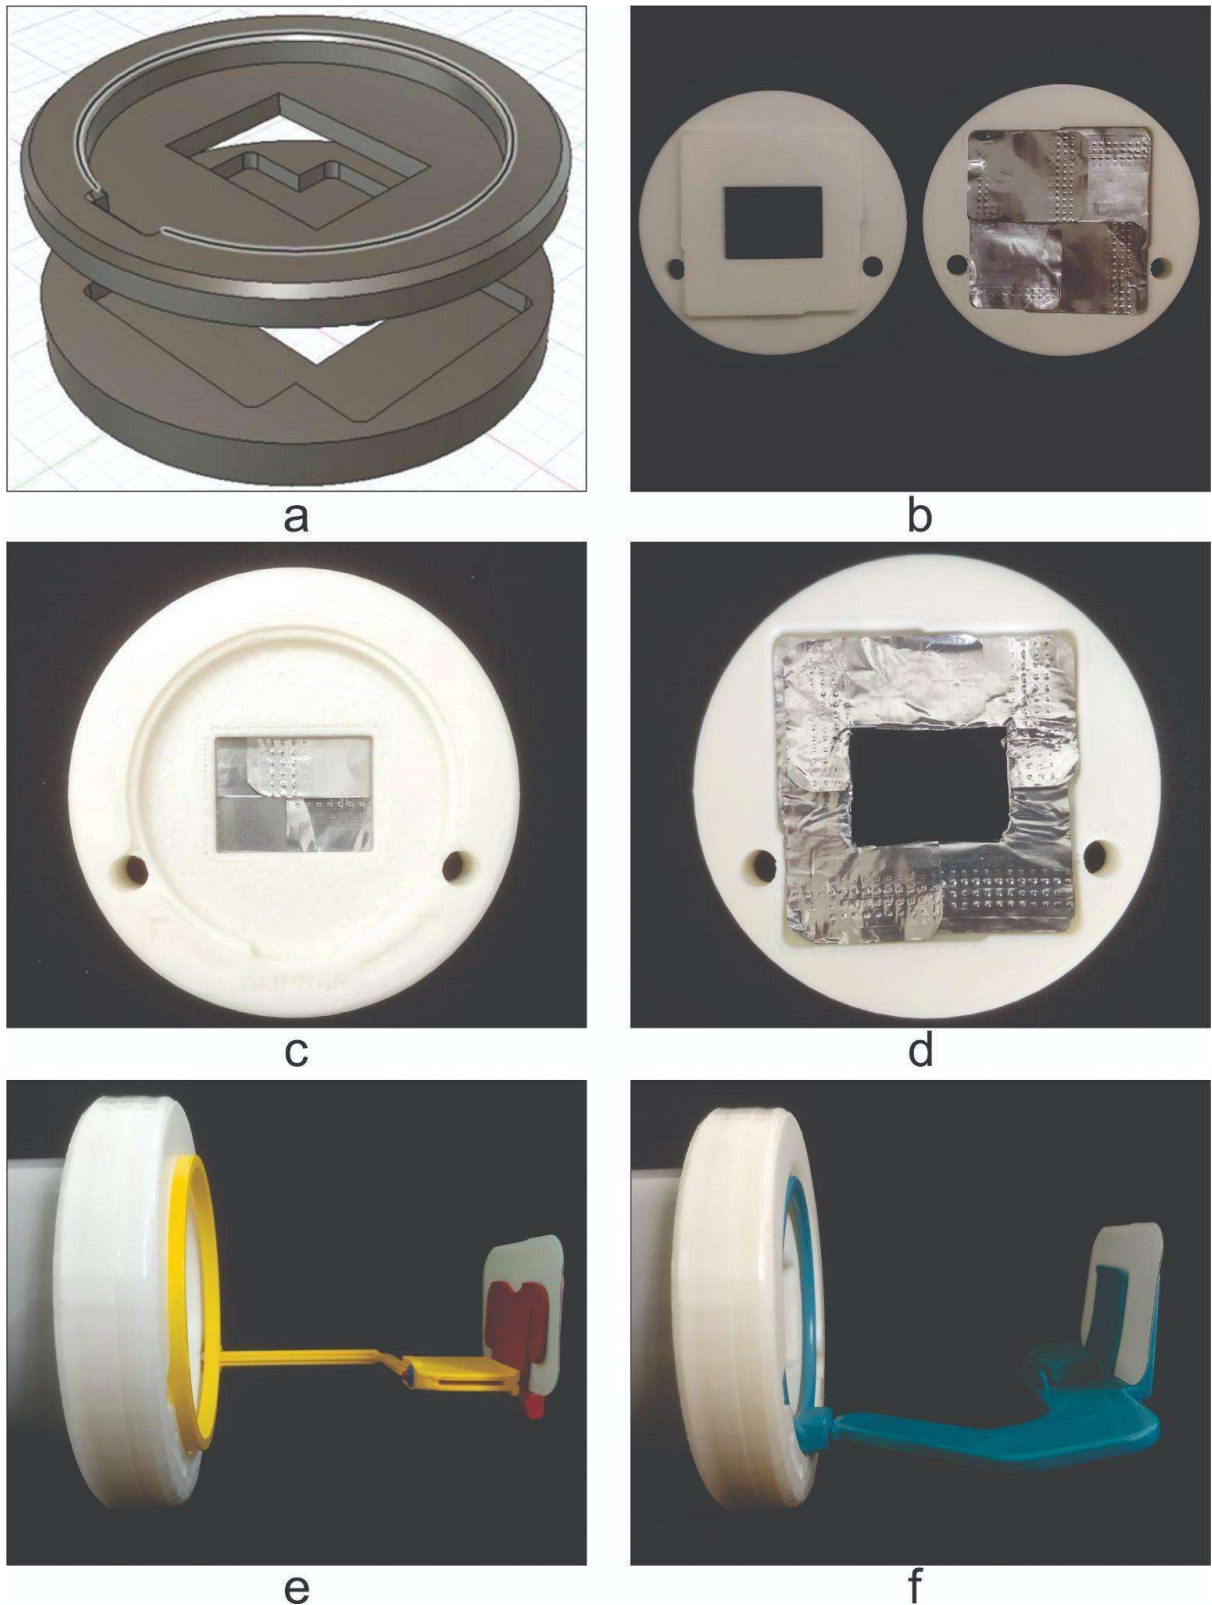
(a) Prototype designed for 3D printing. Prototype printed with lead sheets before (b) and after (c) placing the lid. (d) Collimator with superimposed lead sheets and opened rectangular window. (e) Collimator attached to the X-ray tube guide cylinder and Kerr™ plate holder device. (f) Collimator coupled to the X-ray tube guide cylinder and the Indusbello™ plate holder device.
